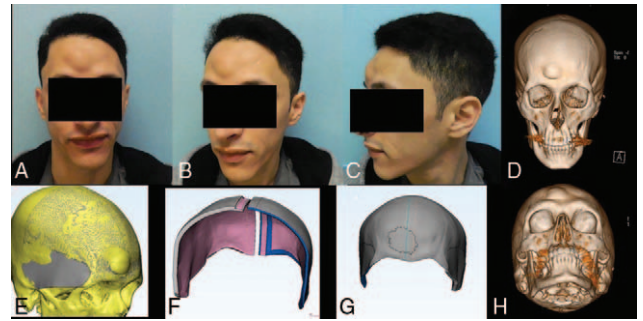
Preoperative photographs (A–C), computed tomography scan imaging (D, E), and virtual planning of 2-piece cranial implants for bilateral frontal skull neoplasm resection and single-stage cranioplasty (F–H).
